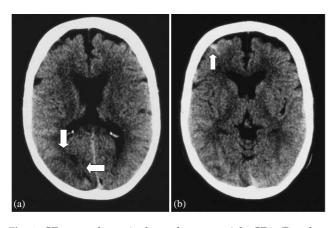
CT scans of case 4 who underwent a right CEA. Five days post-operatively, she suffered unilateral seizures and was noted to have a left-sided weakness. Scans revealed an area of white matter oedema in the right posterior circulation (a) and a focal petechial haemorrhage in the right frontal region (b). She made a full neurological recovery within 24 h.
